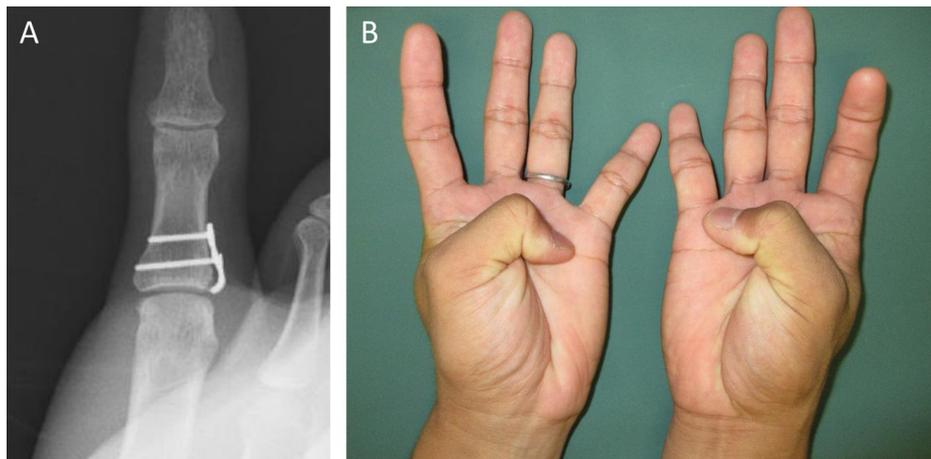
A. A posteroanterior radiograph at 7 months after surgery, showing complete bone union with slight resorption of the fragment as with Case 1. B. The range of motion of the thumb at 7 months after surgery.
